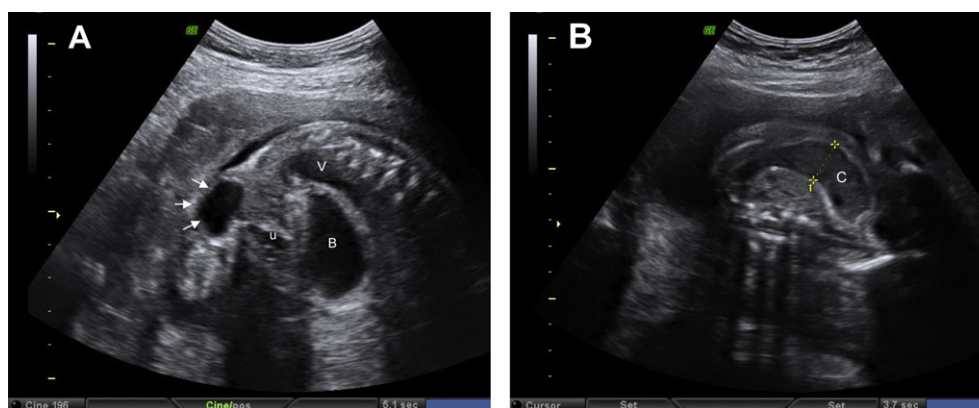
Prenatal ultrasound at 23 weeks of gestation shows (A) dilated bladder, vagina, and urethra, and cystic distal cloacal channel (arrows), and (B) a dilated distal colon. B = bladder; C = colon; U = urethra; V = vagina.
